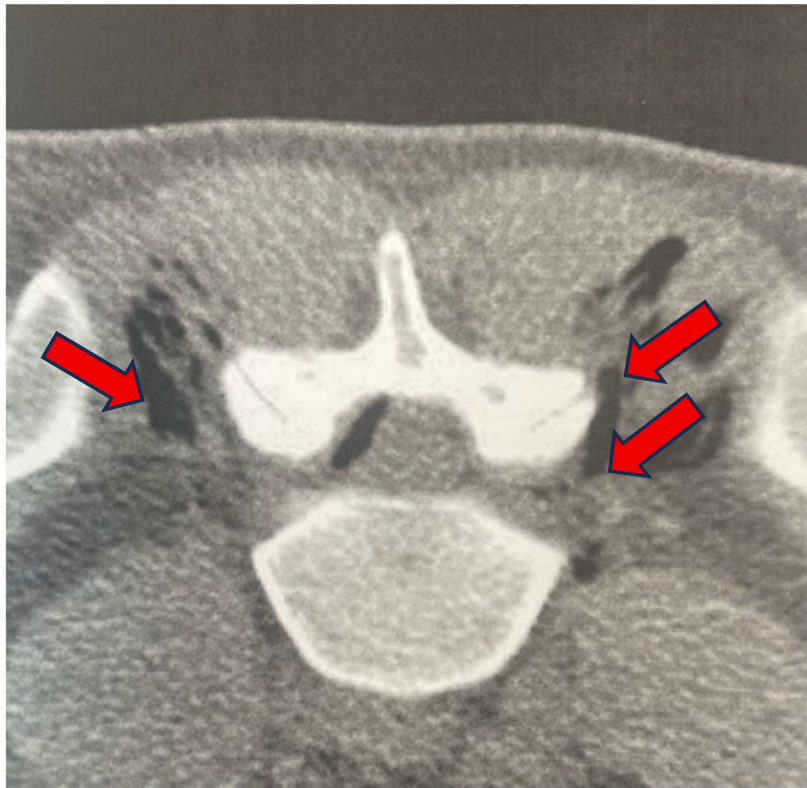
Axial computed tomography scan confirming the distribution of the O₂-O₃ gas mixture (arrows)
